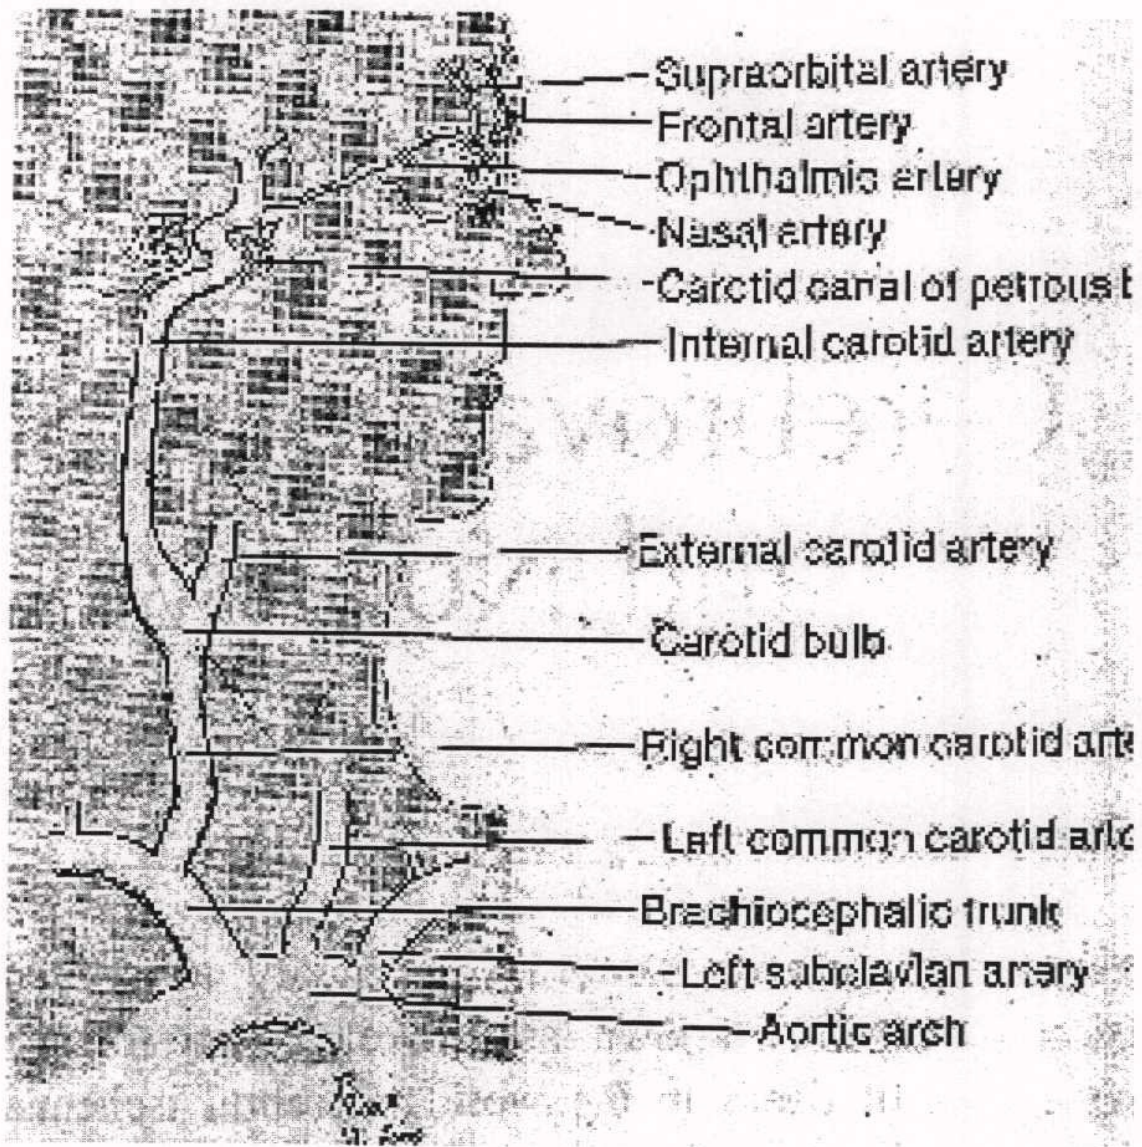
Aortic branches and internal carotid arterial system (Quoted from *Diagnostic ultrasound, 1998*)
